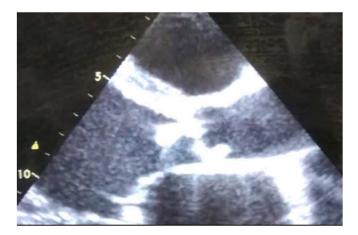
Cardiac ultrasound showing vegetations on the aortic valve.
